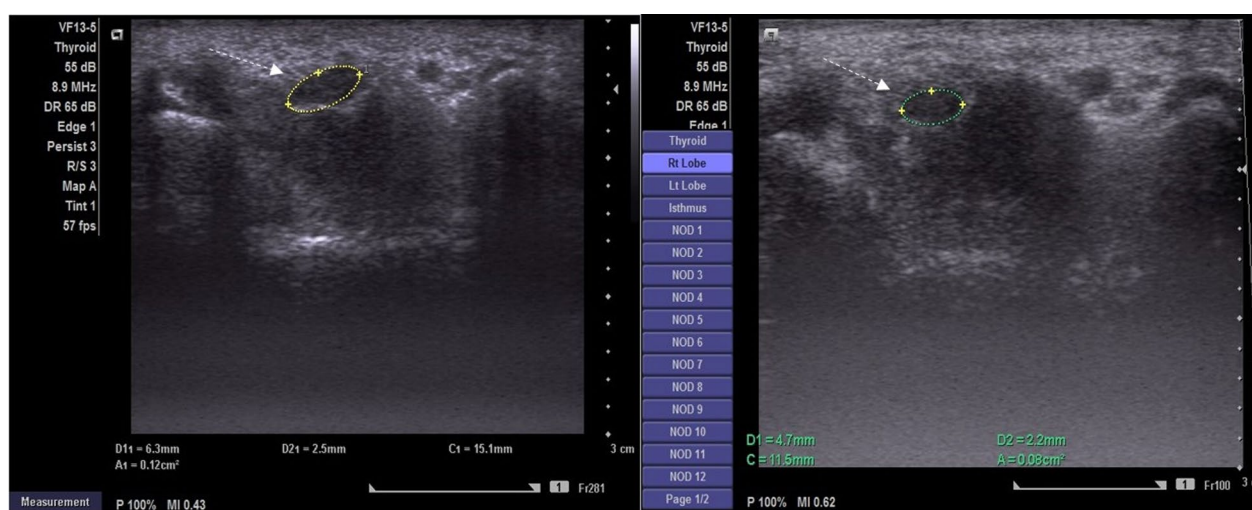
Ultrasound image of the median nerve (dashed arrows) of a 45-year-old patient with mild CTS managed with ultrasound-guided injection. CSA and FR measured 12 mm² and 2.52 before injection (left image) and improved to 8 mm² and 2.13, respectively, at 4 weeks after injection (right image)
